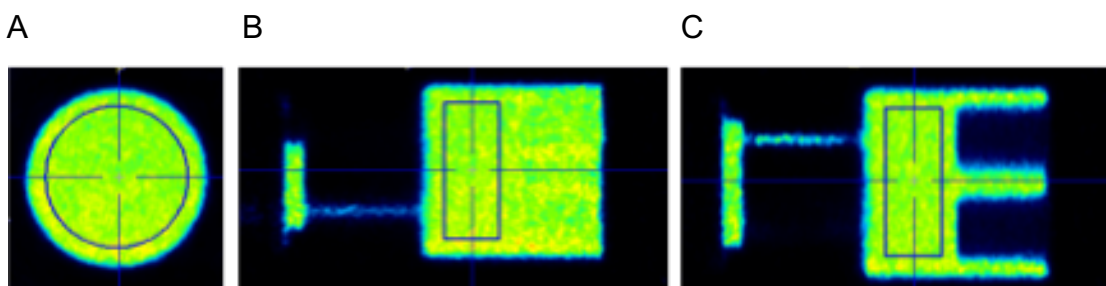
PMOD screen shot showing the VOI placement on the PET IQ uniformity region for SUV measurements. Panels (A), (B) and (C) display the VOI placement from axial, sagittal and coronal views respectively.
